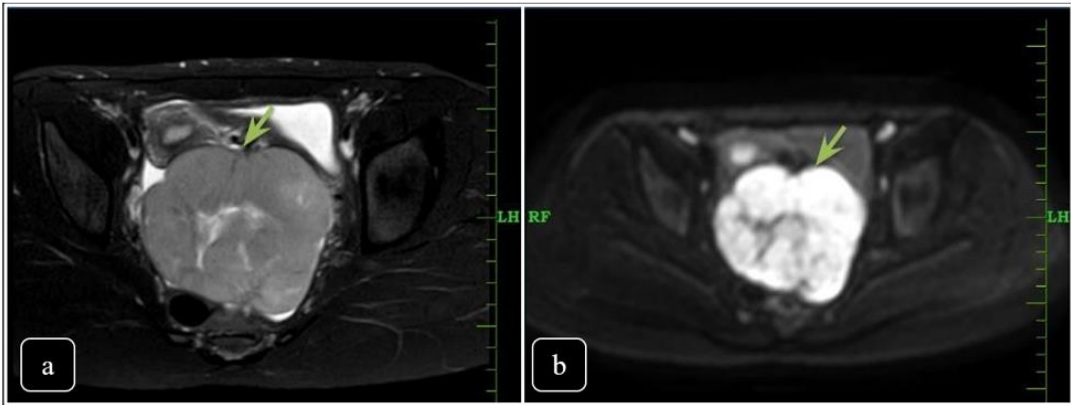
MRI axial SPAIR (a) Shows heterogenous hyperintensity and DWI (b) shows diffusion restriction
